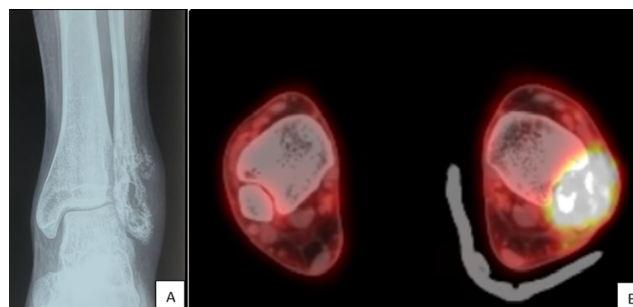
A): Radiograph showing Lytic lesion, B): Axial section showing FDG avid 3.2 x 2.8 x 6.3 cm osteolytic lesion with soft tissue component involving distal end of left fibula with SUV max 7.3
